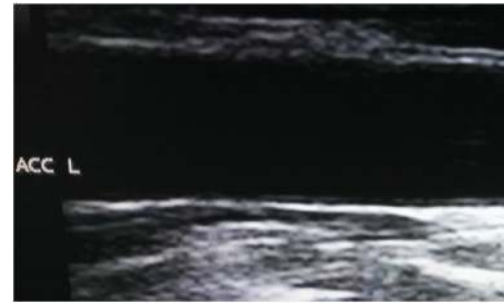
Extracranial duplex sonography of the left common carotid artery (CCA) for patient 1. No atherosclerotic plaques could be detected.
